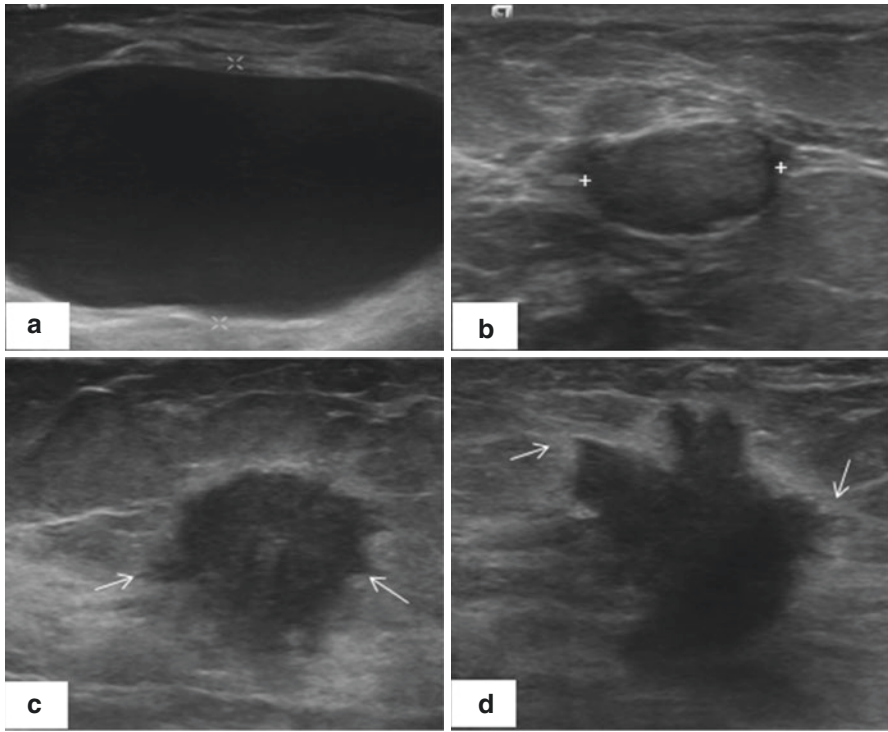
Imaging features on ultrasound: Benign BI-RADS 2 lesions seen as simple anechoic cyst (a) and (b) circumscribed, oval, wider than taller lesion, stable over 2 years (sequential imaging not shown) with posterior enhancement. (c, d) Hypoechoic lesions which are taller than wider, have angular or spiculated margins (arrows in c), thick echogenic rim (arrows in d) and posterior shadowing are highly suspicious for malignancy and are assigned BI-RADS 4c/5
